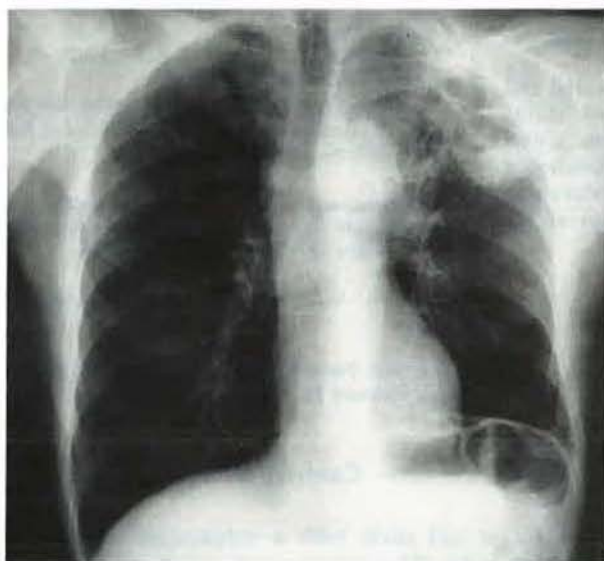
Anteroposterior chest X-ray shows a cavitation of the lung lesion in the left upper lobe. On the bottom of this cavitory lesion a fungus ball is growing.
